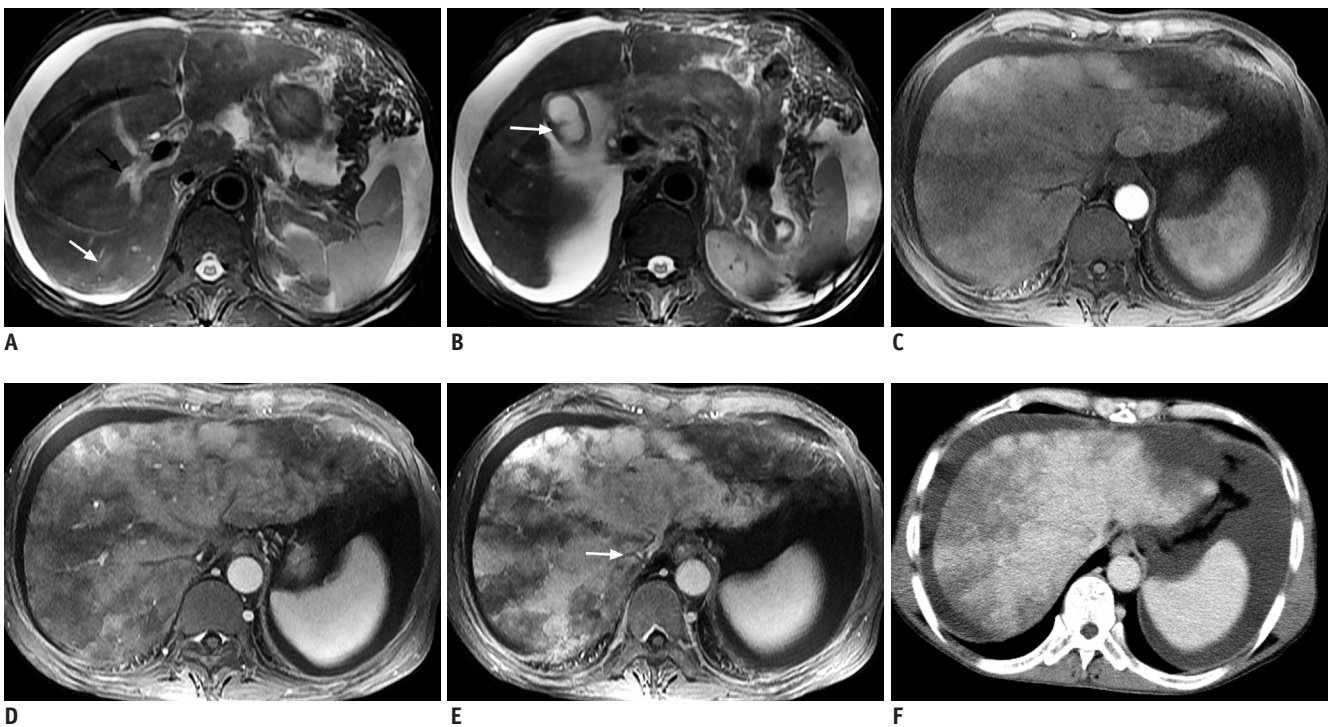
57-year-old man diagnosed with hepatic sinusoidal obstruction syndrome two months after ingestion of *Gynura segetum*. A. Periportal cuffing (black arrow) and subtle parenchymal heterogeneity (white arrow) are demonstrated on fat-suppressed T2-weighted MRI. B. Gallbladder wall thickening (arrow) is also demonstrated. C-E. Patchy enhancement is well demonstrated on T1-weighted gadolinium-enhanced MRI (C: artery phase, D: portal phase, E: hepatic venous phase), especially on portal and hepatic venous phase. Note middle and left main hepatic vein are narrowed, while right main hepatic vein is unenhanced (arrow). F. Hepatic venous phase CT from same patient also demonstrates patchy liver enhancement.
